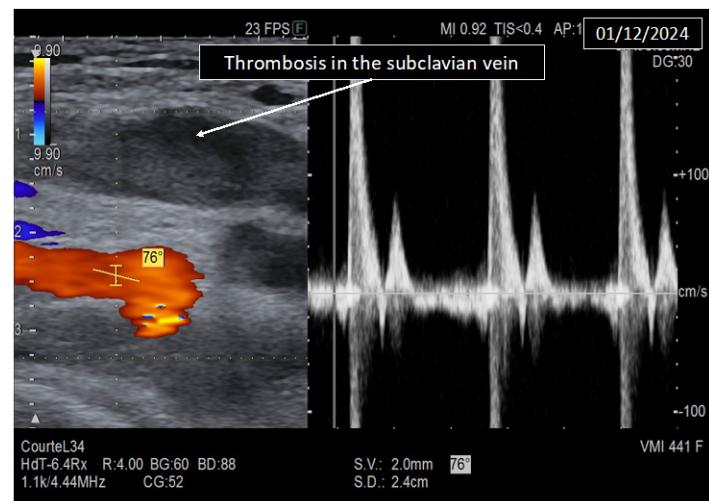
Doppler of the right upper limb showing thrombosis in the right subclavian vein.
